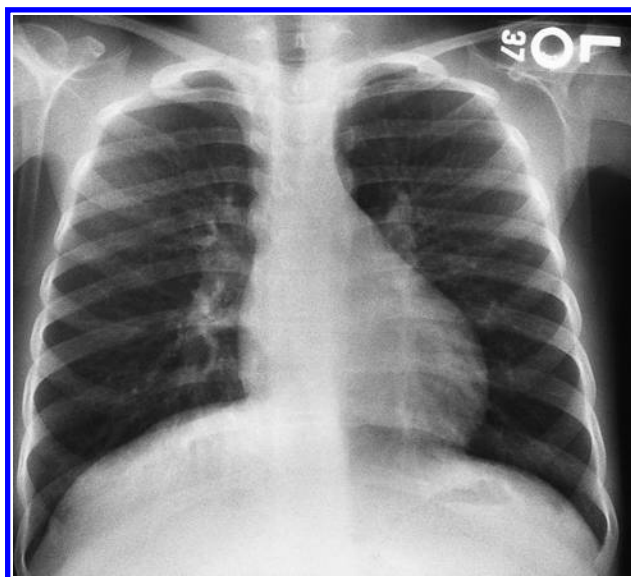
Roentgenogram of the chest of CT, a ten-year-old girl with α_1 -AT deficiency. There were no pulmonary symptoms, but bronchial markings were increased as linear densities, there was hilar prominence, and there was evidence of hyperinflation.
